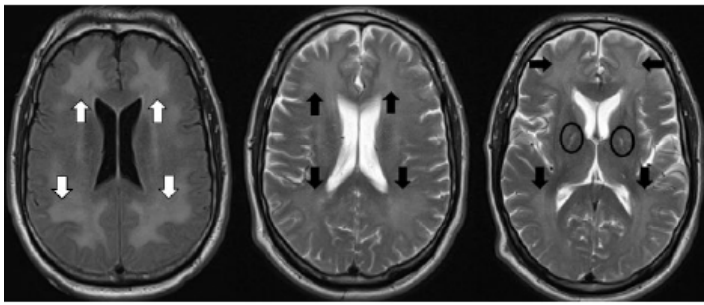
Magnetic resonance imaging two days after onset of neuropsychiatric decline (20 days after initial visit) showing more apparent symmetric hyperintensity in frontal and parietal lobes (axial FLAIR sequence on far left with white arrows, axial T2 sequence in middle and far right with black arrows) and hyperintensity of the bilateral globi pallidi (ovals) with otherwise normal-appearing gray matter.
